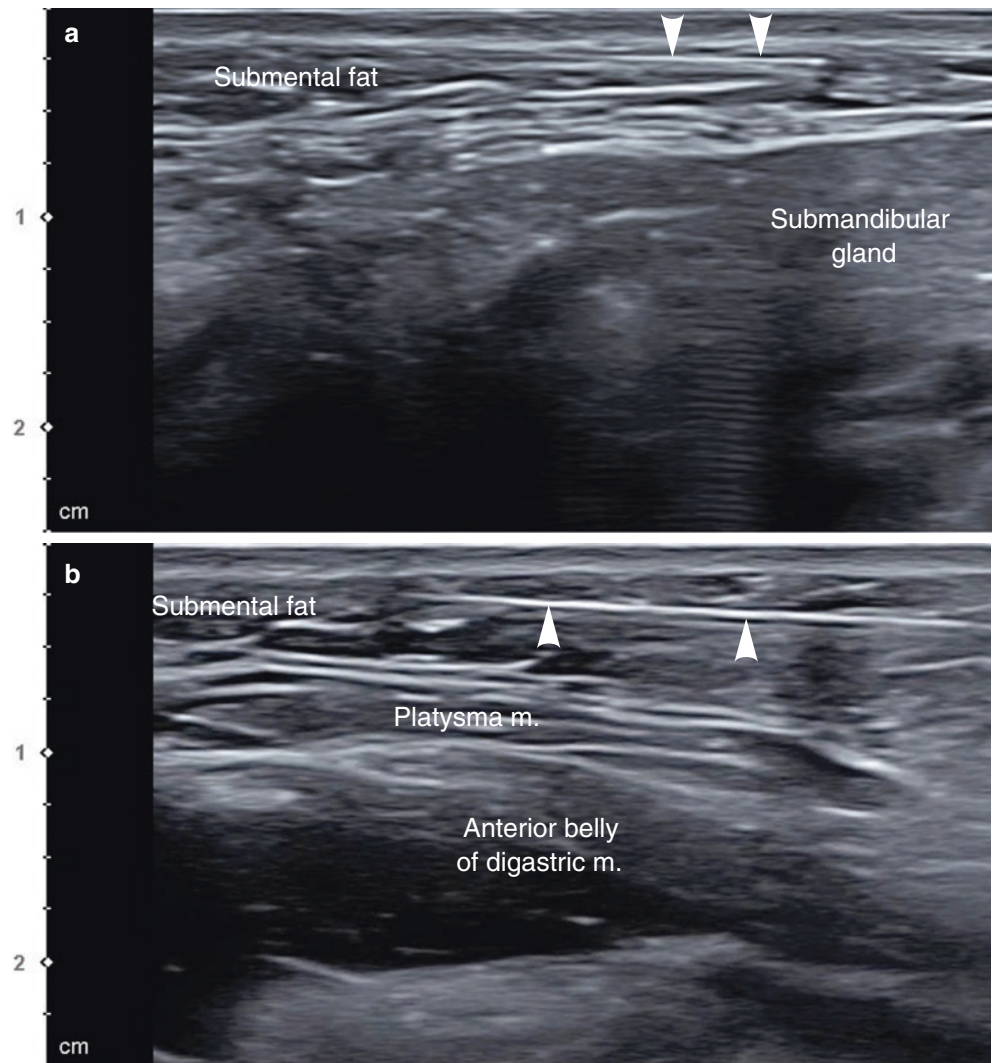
Ultrasonography-guided multidirectional cog thread insertion for neck lift. (a) Above the submandibular gland, B mode (transverse view, 15 MHz by linear transducer) and (b) within the submental fat above the platysma muscle, B mode (transverse view, 15 MHz by linear transducer) (arrowheads: thread cannula). (Published with kind permission of © Ji-Soo Kim 2020. All Rights Reserved)
